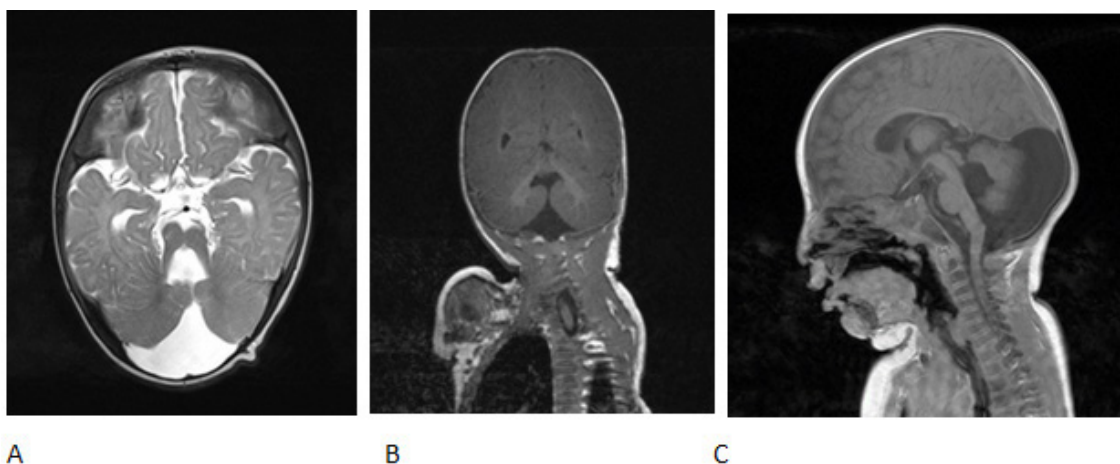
MRI images of brain showing molar tooth sign, A - AX T2; B - COR T1; C - SAG T1
